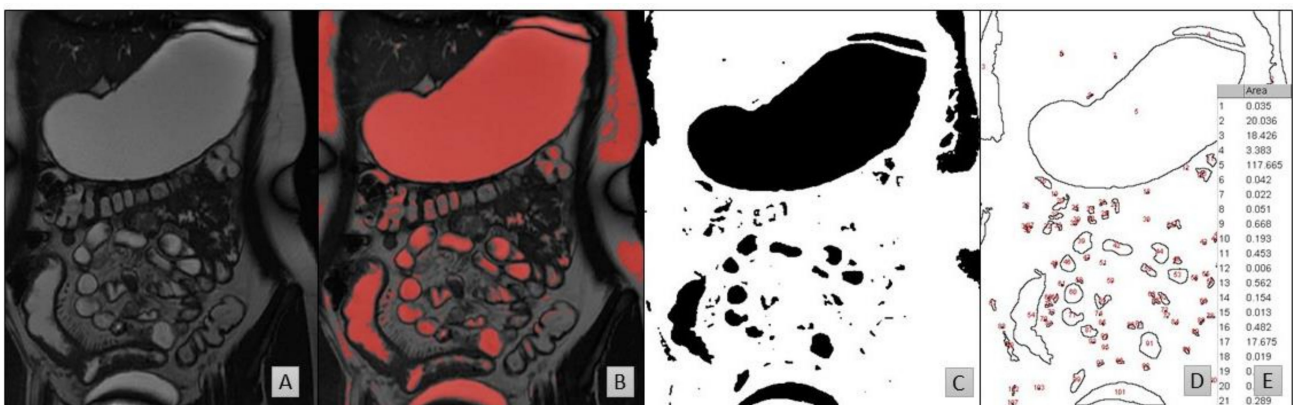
MRI slices taken from a 16-year-old fed female. (A) The original MRI slice. (B) The same slice after thresholding in Horos based on the CSF. (C) The same slice after filtering the red pixels on a black-on-white print in ImageJ. (D) The results of particle analysis show the outlines of the regions of interest and (E) an example extract of the data generated following calculation of the respective areas from (D).
